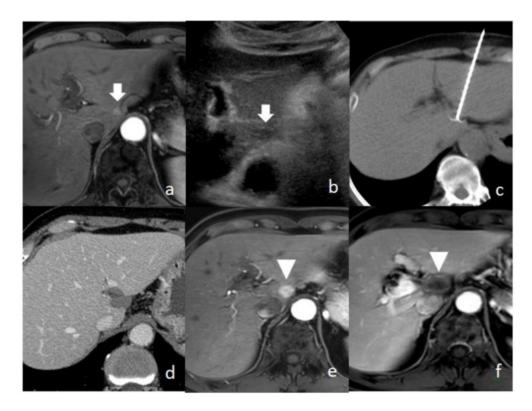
A 71 year-old man with a 1 cm HCC in Spiegel portion of caudate lobe (arrow in a, b) RF ablation was performed via anterior left lobe approach (c). CT after ablation showed complete ablation (d). At two years follow up, MRI showed local tumor progression (arrowhead in e). Second RF ablation was performed by using the same technique and complete ablation was achieved (arrowhead in f).
